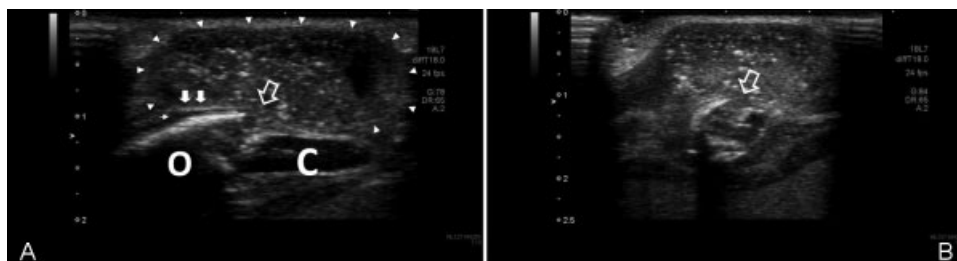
(A) Longitudinal and (B) transverse ultrasound images of the right ninth rib region on the day of admission, demonstrating a 22×10 mm mushroom-shaped subperiosteal mass (arrowheads) of the right ninth rib, with heterogeneous echotexture including fluid with a relatively hyperechoic sediment. Gentle pressure over the mass with the probe induced motion, confirming the fluid content. (A) The echolucent cartilaginous (C) and shadowing osseous (O) portions are visible. The mass communicates with the medullary cavity of the rib at the costochondral junction, where a prominent discontinuity between the osseous and cartilaginous parts of the rib signifies a fracture (open arrow). Fluid adjacent to the cortex of the rib, elevating the periosteum by approximately 2 mm (narrow arrow), and moderate thickening of the periosteum are also shown (bold arrows).
